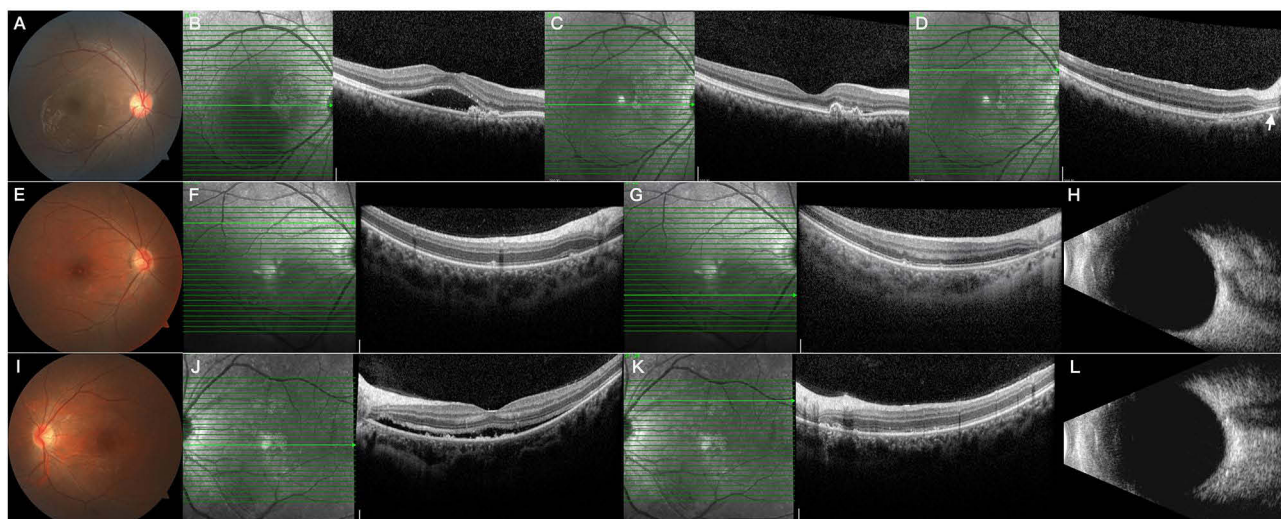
Multimodal Fundus Imaging in Case 1 and Case 8. (A–D) represent multimodal imaging of Case 1: (A and B) demonstrate RPE elevation with subneurosensory fluid at initial examination; (C and D) post chemotherapy show resolution of subneurosensory fluid with new onset outer retinal atrophy superotemporal to the optic disc (white arrows). (E–L) correspond to Case 8: (E and I) reveal multiple yellow white punctuate lesions in the posterior pole; (F, G, J and K) exhibit RPE layer abnormalities with subneurosensory fluid on SD-OCT; (H and L) display B-scan ultrasonography showing no significant inflammatory echoes in the vitreous cavity.
